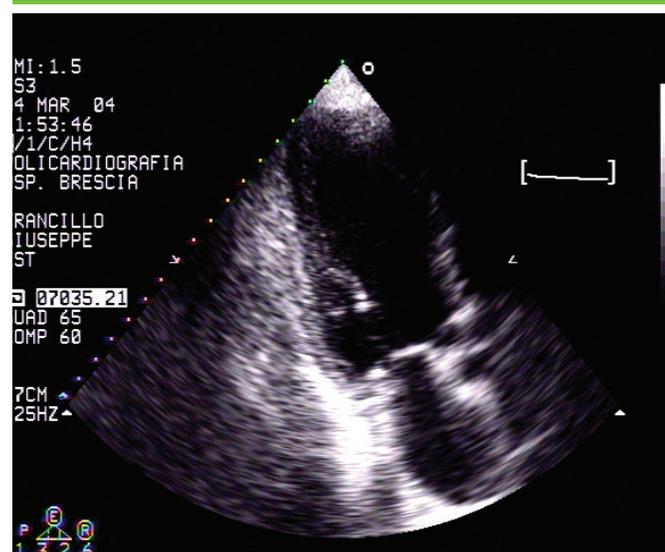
2D apical three-chamber view showing calcific aortic valve, mitral annulus and papillary muscle.
